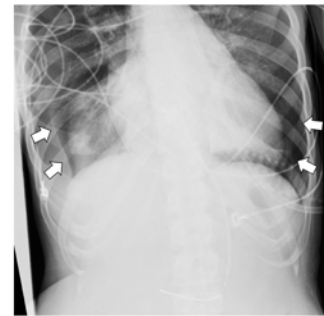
Bilateral pneumothoraces after extubation while on noninvasive positive pressure ventilation. Upon recognition of this finding (radiograph performed for routine nasogastric tube placement confirmation) bilateral tube thoracostomies were performed.
